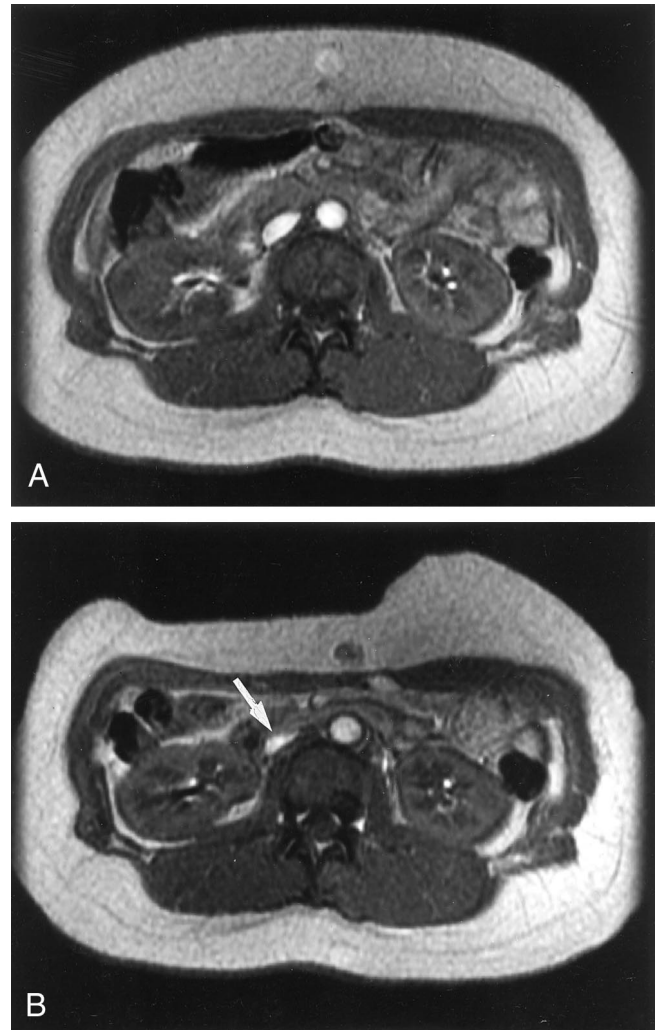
T1-weighted images of the abdomen at the level of the abdominal compression, just below the right costoxiphoid angle. A, At rest. B, With abdominal compression. The IVC (white arrow) is markedly compressed compared with A. Note the deformity-flattening of the anterior subcutaneous tissues and the abdominal musculature by the compression device.
